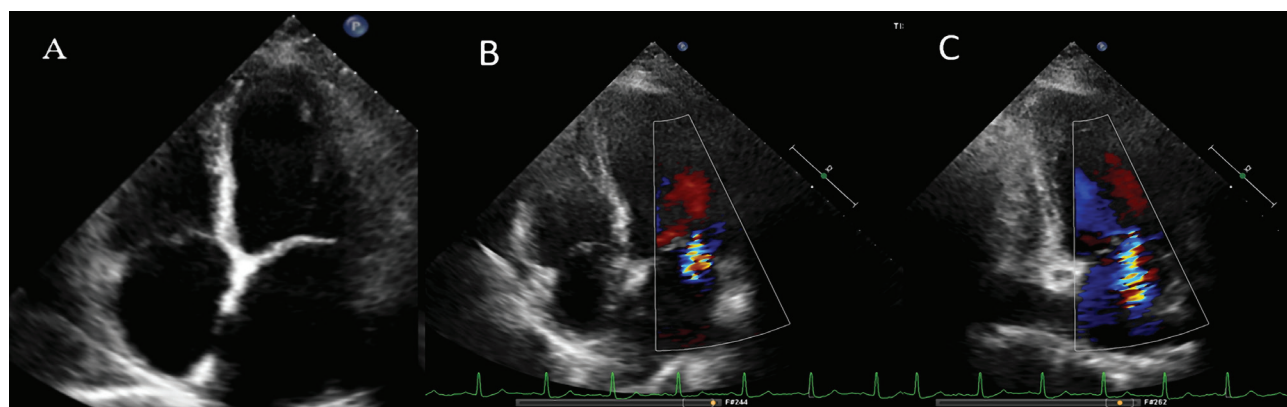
Transthoracic echocardiography. A – Apical 4-chamber view: LV and RV with normal size; B – Apical 4-chamber view, color Doppler; C – Apical 2-chamber view, color Doppler: Mild mitral regurgitation. LV – left ventricle; RV – right ventricle.
